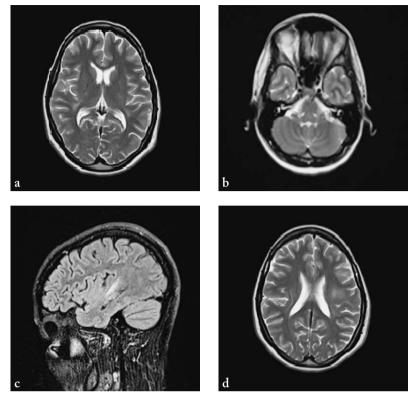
MRI of the brain two weeks after first clinical presentation showing complete regression of earlier infratentorial lesions (a) and significant regression of supratentorial lesions (b-d).
